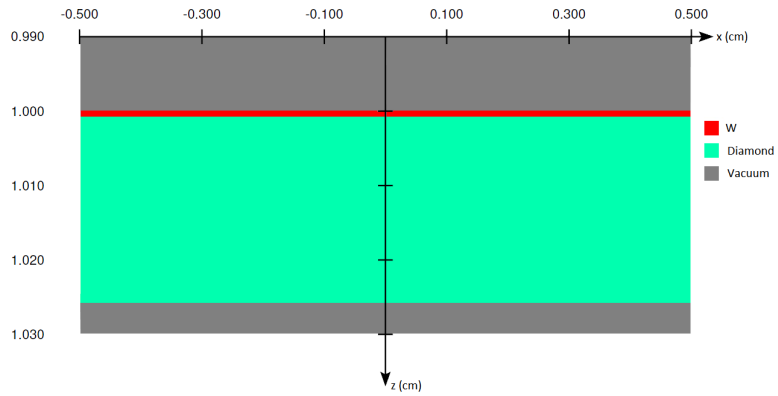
Design of the 160 kV FeinFocus transmission X-ray tube without internal molybdenum structures as specified in BEAMnrc
